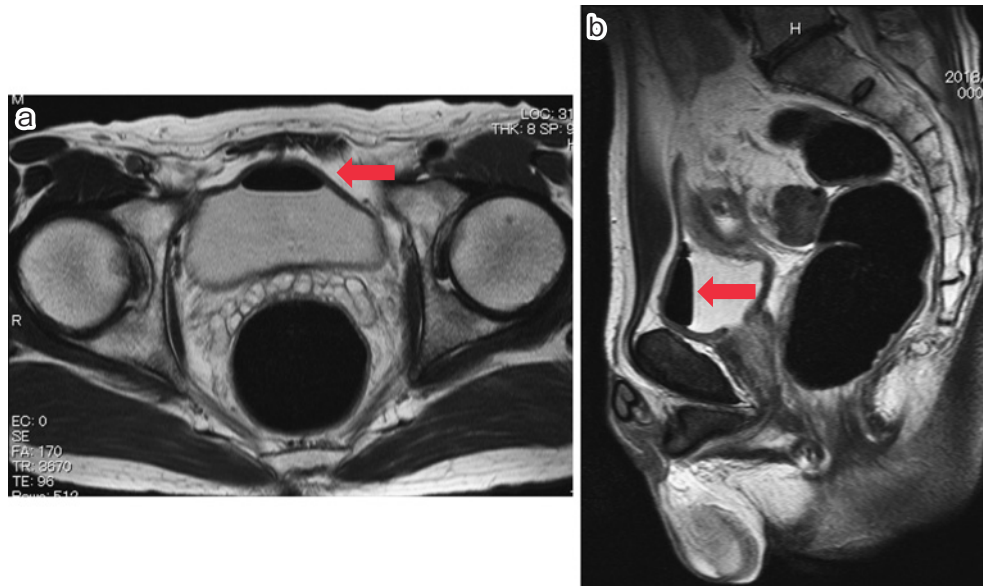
MRI (T2) showed the free air in the bladder (arrow).
